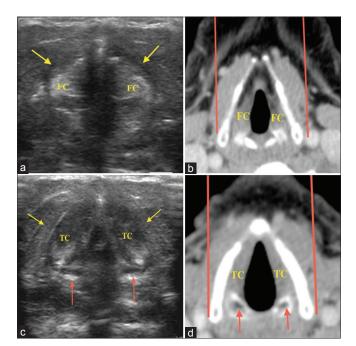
(a) Axial section at the level of larynx (step 6), i.e., false vocal cords, using linear transducer. (b) Corresponding computed tomographic section of (a) (red lines – representing the limit of ultrasound scan extent). (c) Axial section at the level of larynx demonstrating sonoanatomy of step 7 structures. (d) Corresponding computed tomographic section of (c) (red lines – representing limit of ultrasound scan extent) FC: False vocal cords; TC: True vocal cords; Yellow arrows, Thyroid cartilage; Red arrows, Arytenoid cartilages
